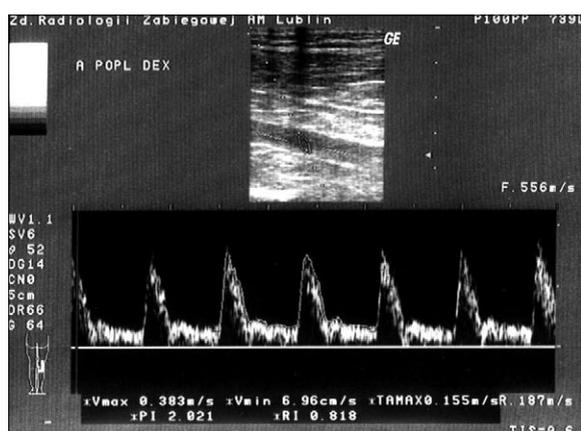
Normal Doppler spectral waveforms taken from popliteal arteries of healthy patients. HRI values – 0.387 and 0.536.
